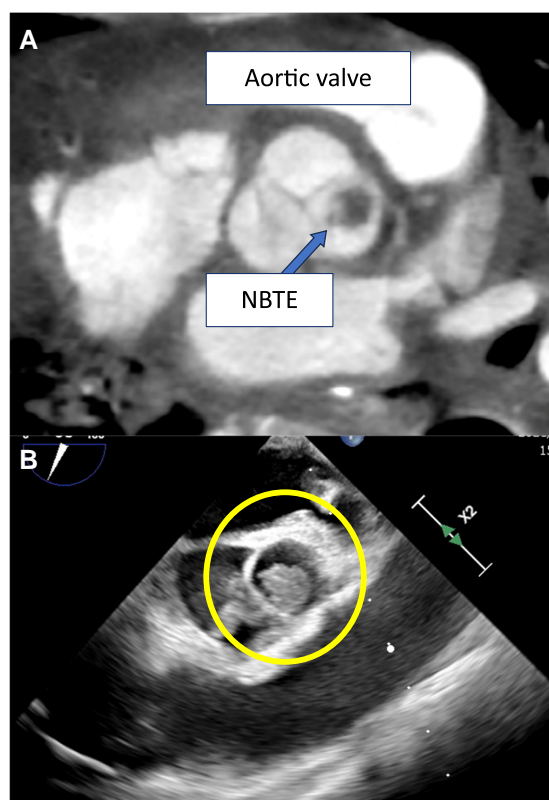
(A) Contrast-enhanced computed tomography. A mass on the left coronary cusp (arrow). (B) Transoesophageal echocardiogram. Intermittent obstruction of the left coronary artery ostium occurred due to the transient proximity of the mobile mass ($10 \times 10 \times 8$ mm) (circle).
